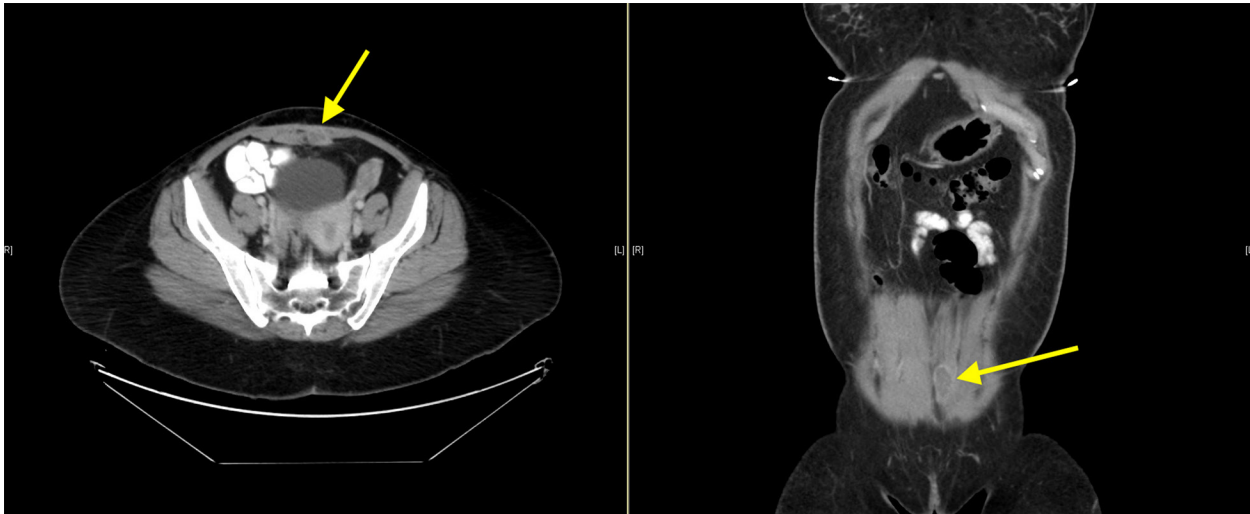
An abdomen/pelvis CT scan with contrast confirmed the presence of a 3.4 cm fluid collection/abscess (shown in yellow arrows). CT, computed tomography.
